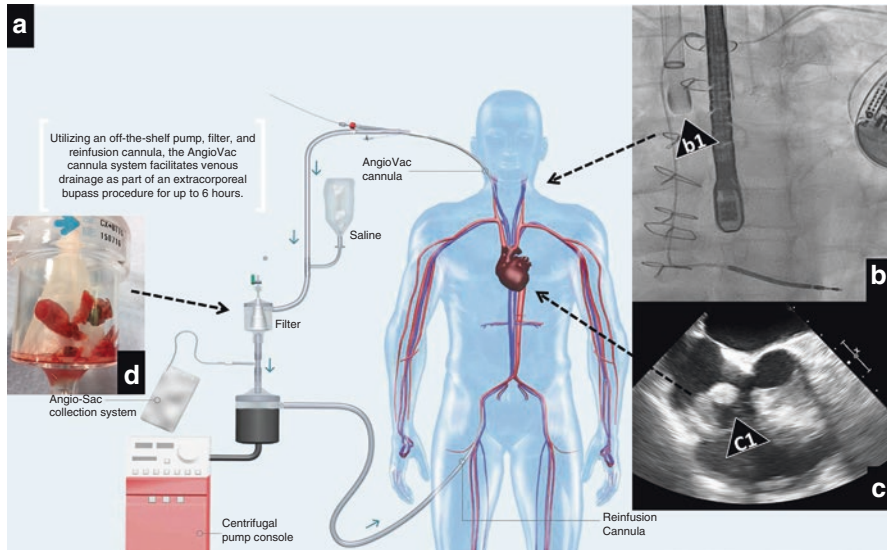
Representation of the AngioVac system. AngioVac system (Panel a) (the image in the background is reproduced from Ram et al. [23] with permission). The AngioVac cannula (b1), inserted through the jugular vein under X-ray guidance (Panel b), drains the target vegetation (c1) under TEE guidance (Panel c), which is collected in the filter (Panel d). A reinfusion cannula is also inserted in the femoral vein to allow blood reinfusion
